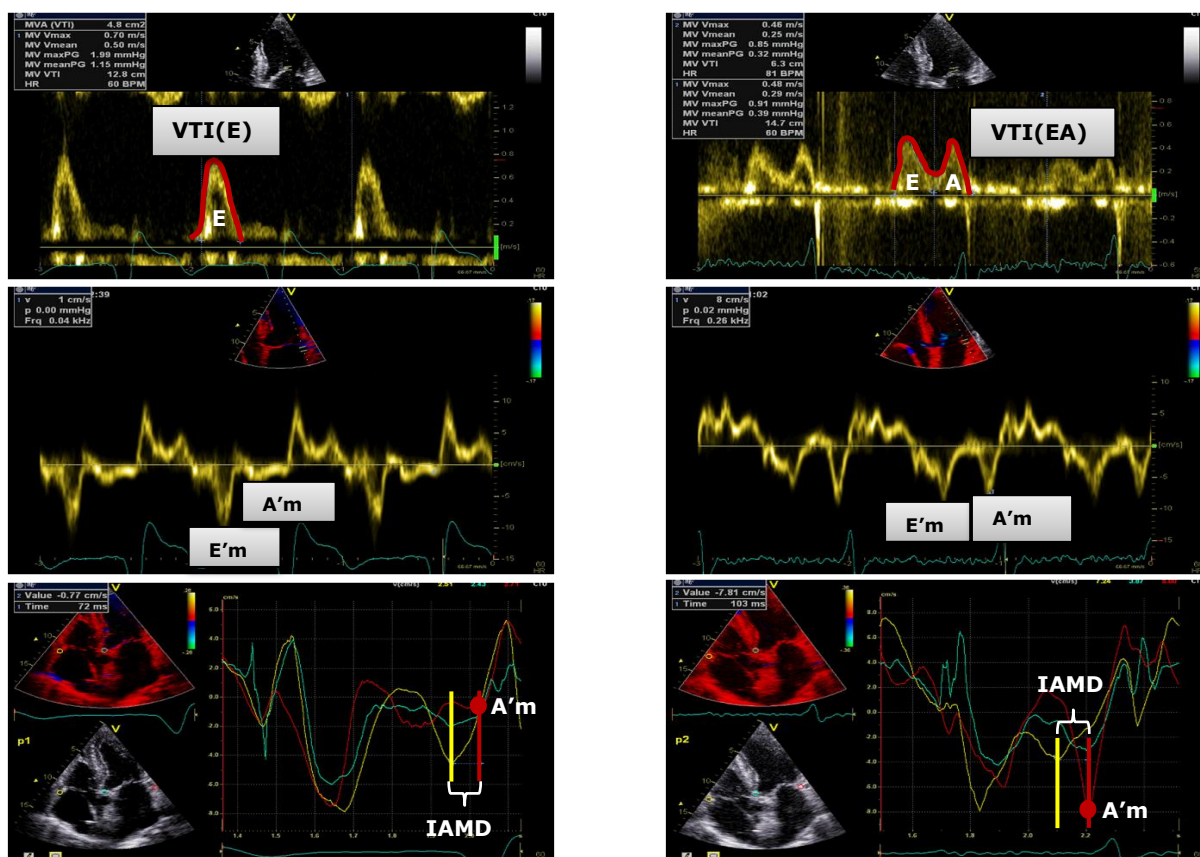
Optimisation of the AV delay via the iterative MI VTI method (left = before optimisation; right = after optimisation). The panels on top show the optimisation of the AV delay by determination of the largest VTI on pulsed wave Doppler. The panels in the middle show a higher late diastolic myocardial velocity at the lateral mitral annulus level (A'm) after optimisation on tissue Doppler. The panel at the bottom show a higher late diastolic myocardial velocity at the lateral mitral annulus level (A'm) after optimisation on colour tissue Doppler. Also marked is the interatrial mechanical delay (IAMD), defined by the time interval between the annular late diastolic peak velocity at the lateral tricuspid (yellow) and mitral level (red).
